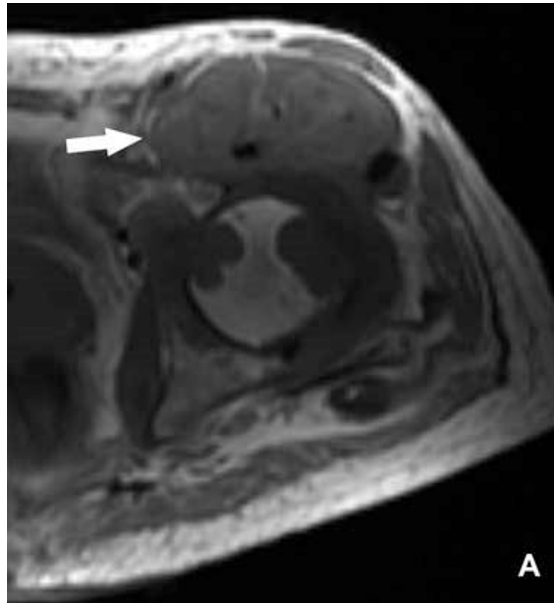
MRI of the pelvis. Axial T1 (TR 566 /TE 13) -weighted MR image of the pelvis. Thickened synovium erodes the left femoral head. The iliopsoas muscle is thickened (arrow).
